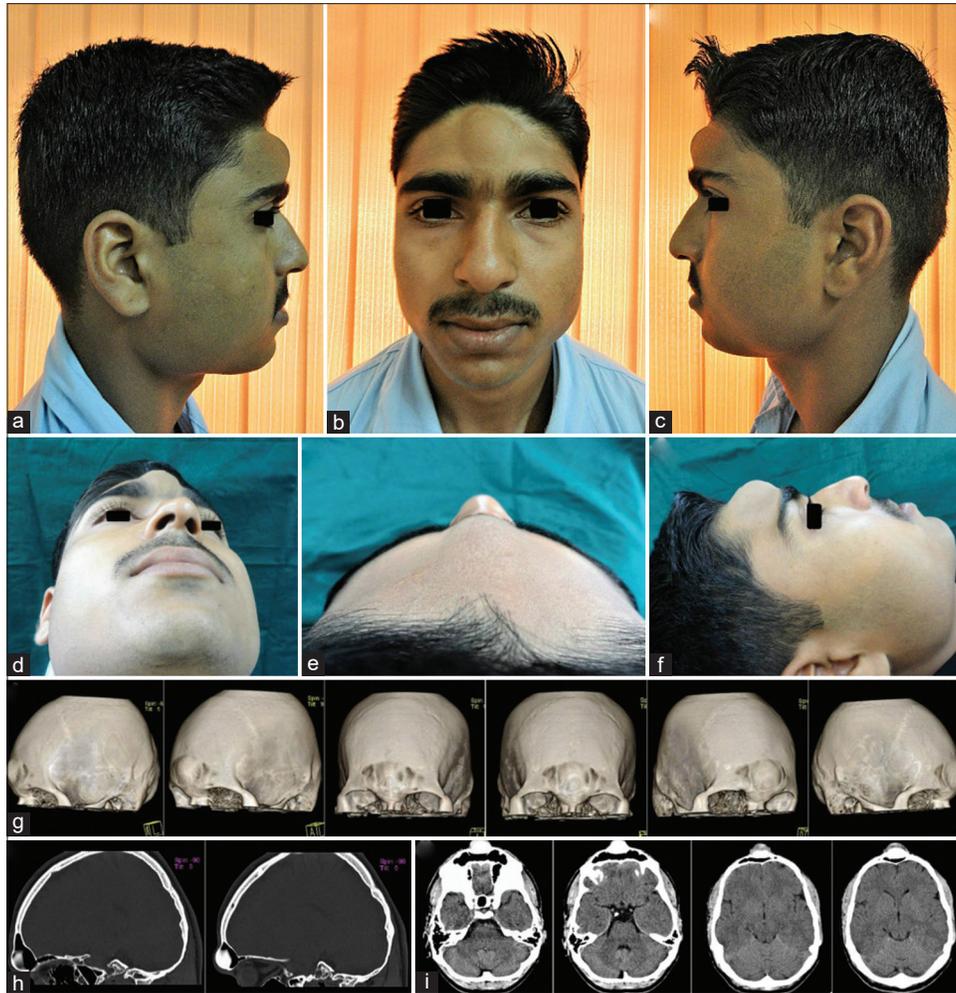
(Case 2) (a-f) Prominent, bony hard, nontender swelling with smooth margins over the forehead region. (g) Noncontrast computed tomography showed the ellipsoid morphology of the bony enlargement involving the glabella region, without the involvement of the adjoining orbital or nasal bones, suggestive of the monostotic variant of fibrous dysplasia or Osteoma. (h and i) Sagittal and axial sections revealed a ground-glass appearance, with enlargement of the outer table of the frontal sinus, encroaching into the sinus cavity thereby reducing its volume
